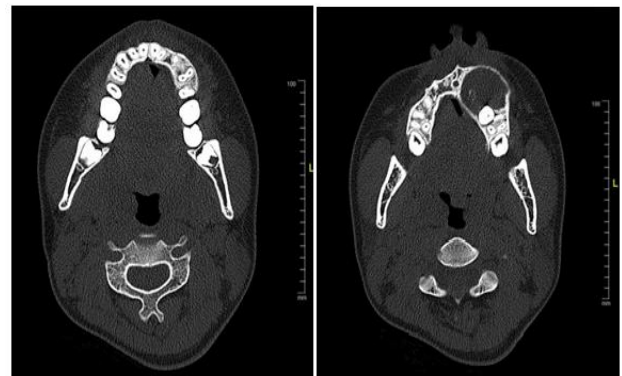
Axial CT scan of the patient showing showing unerupted tooth (left premolar) and the origin of the cyst from maxillary bone.
